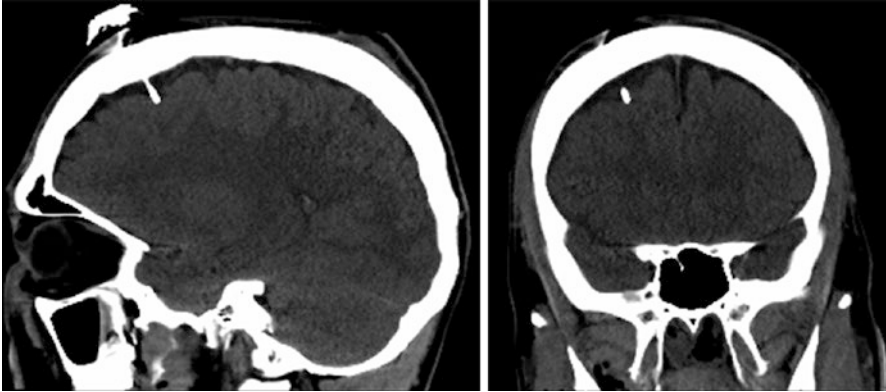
CT scan demonstrating an intraparenchymal pressure monitor (bolt)
